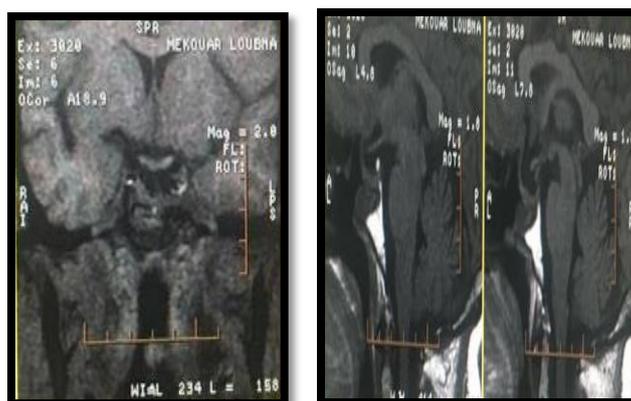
2 months postoperative MRI, T1 sequence, coronal and sagittal section showing complete excision of the lesion
